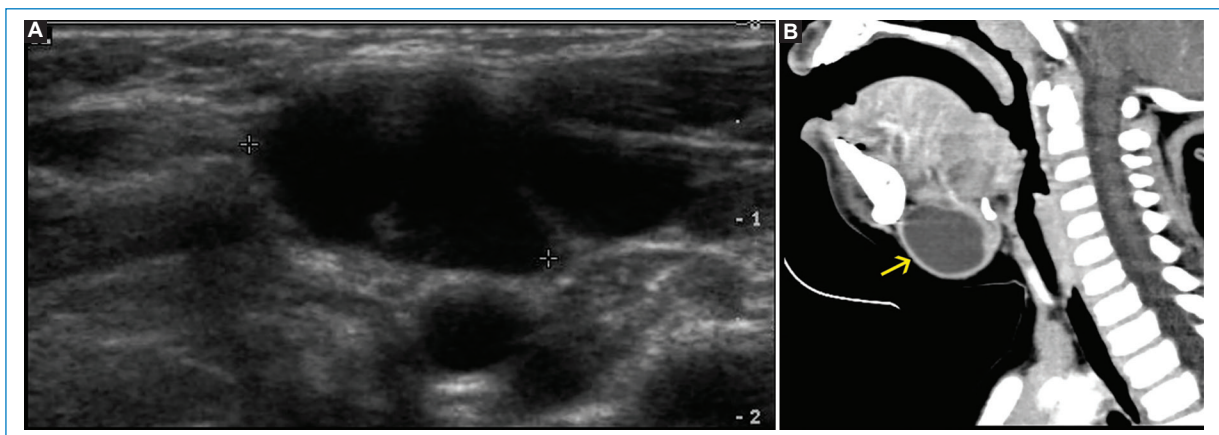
Sublingual volume increase corresponding to sublingual cystic lesions visible on ultrasound (A) and computed tomography (B), which corresponded to lymphangiomas.
